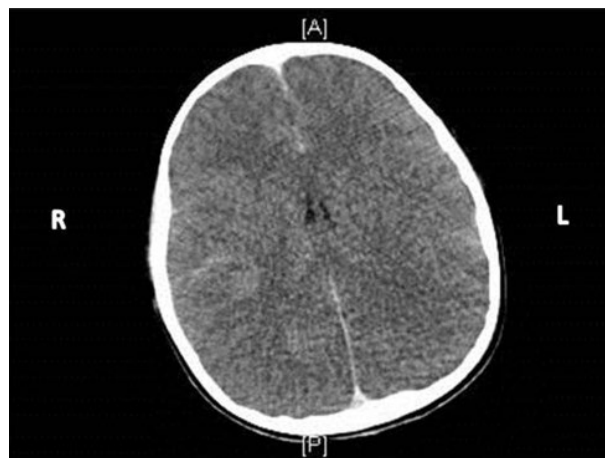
CT head without contrast in 1-year-old victim of "shaken baby syndrome" showing diffuse axonal injury with diffuse effacement of the sulci and slit-like ventricles.
